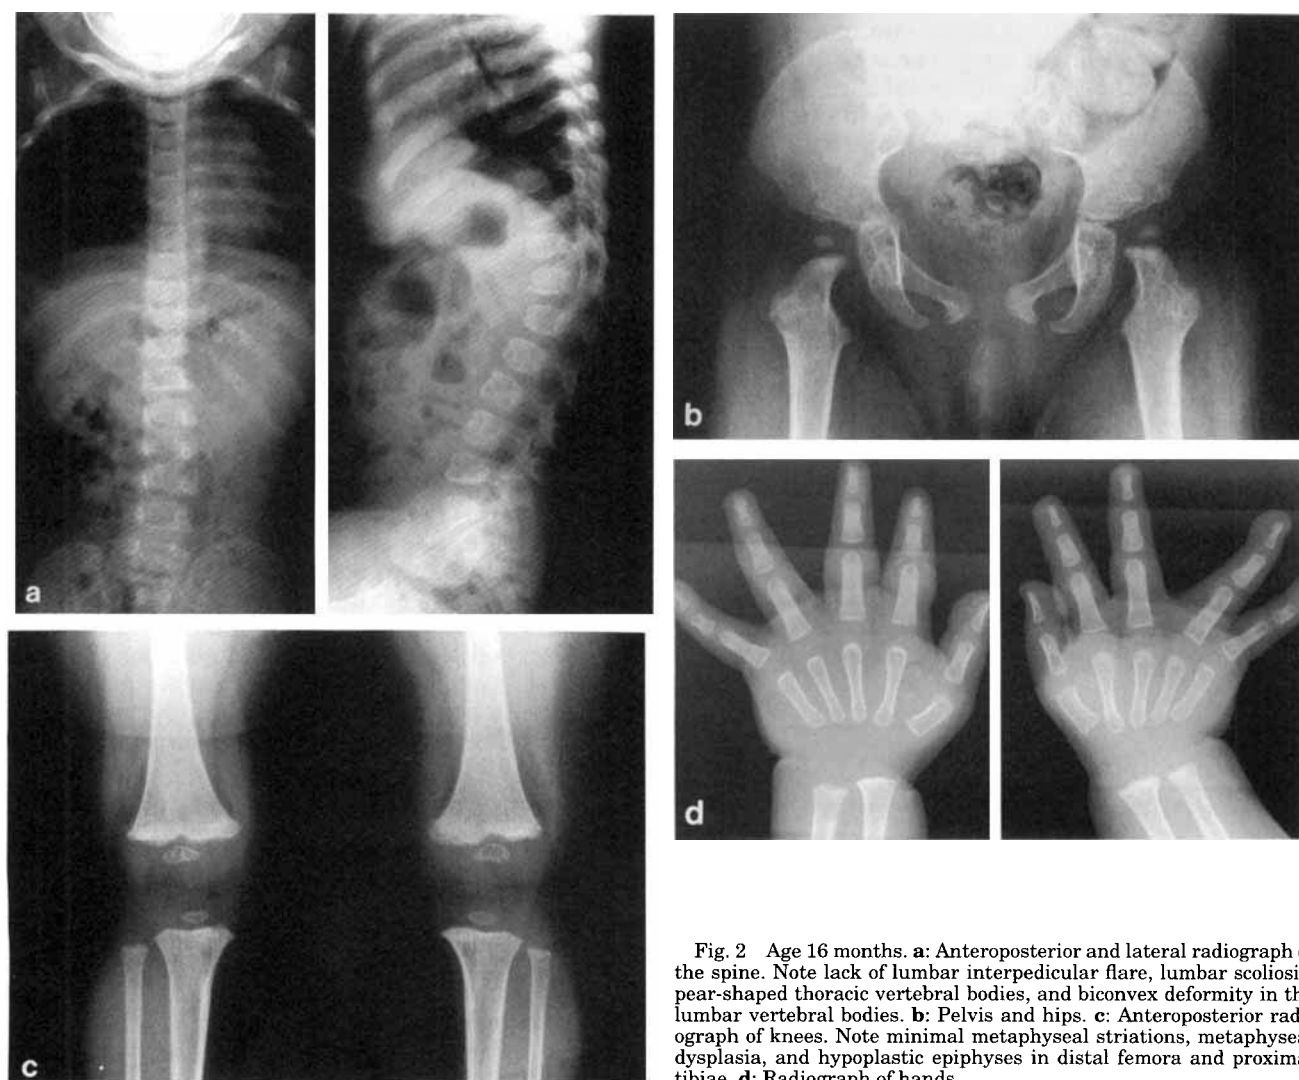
Age 16 months. a: Anteroposterior and lateral radiograph of the spine. Note lack of lumbar interpedicular flare, lumbar scoliosis, pear-shaped thoracic vertebral bodies, and biconvex deformity in the lumbar vertebral bodies. b: Pelvis and hips. c: Anteroposterior radiograph of knees. Note minimal metaphyseal striations, metaphyseal dysplasia, and hypoplastic epiphyses in distal femora and proximal tibiae. d: Radiograph of hands.
